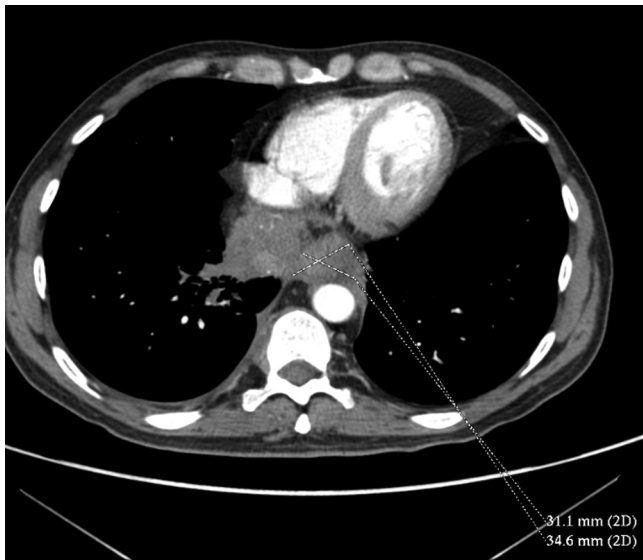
Chest computed tomography: mass in the posterior-inferior mediastinum obliterating the oesophagus and surrounding the inferior vena cava.
